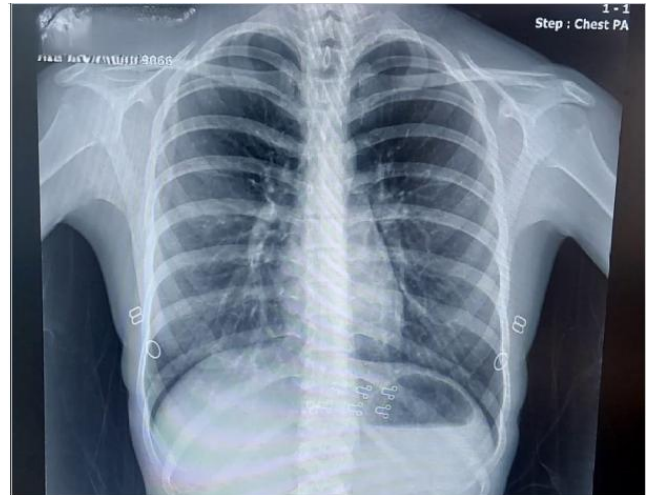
Follow-up posteroanterior chest radiograph showing complete radiographic resolution.
